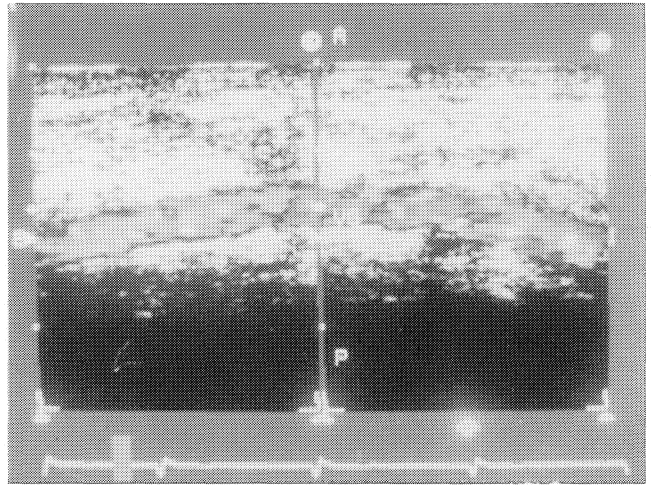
Ultrasonic imaging shows patent graft.
